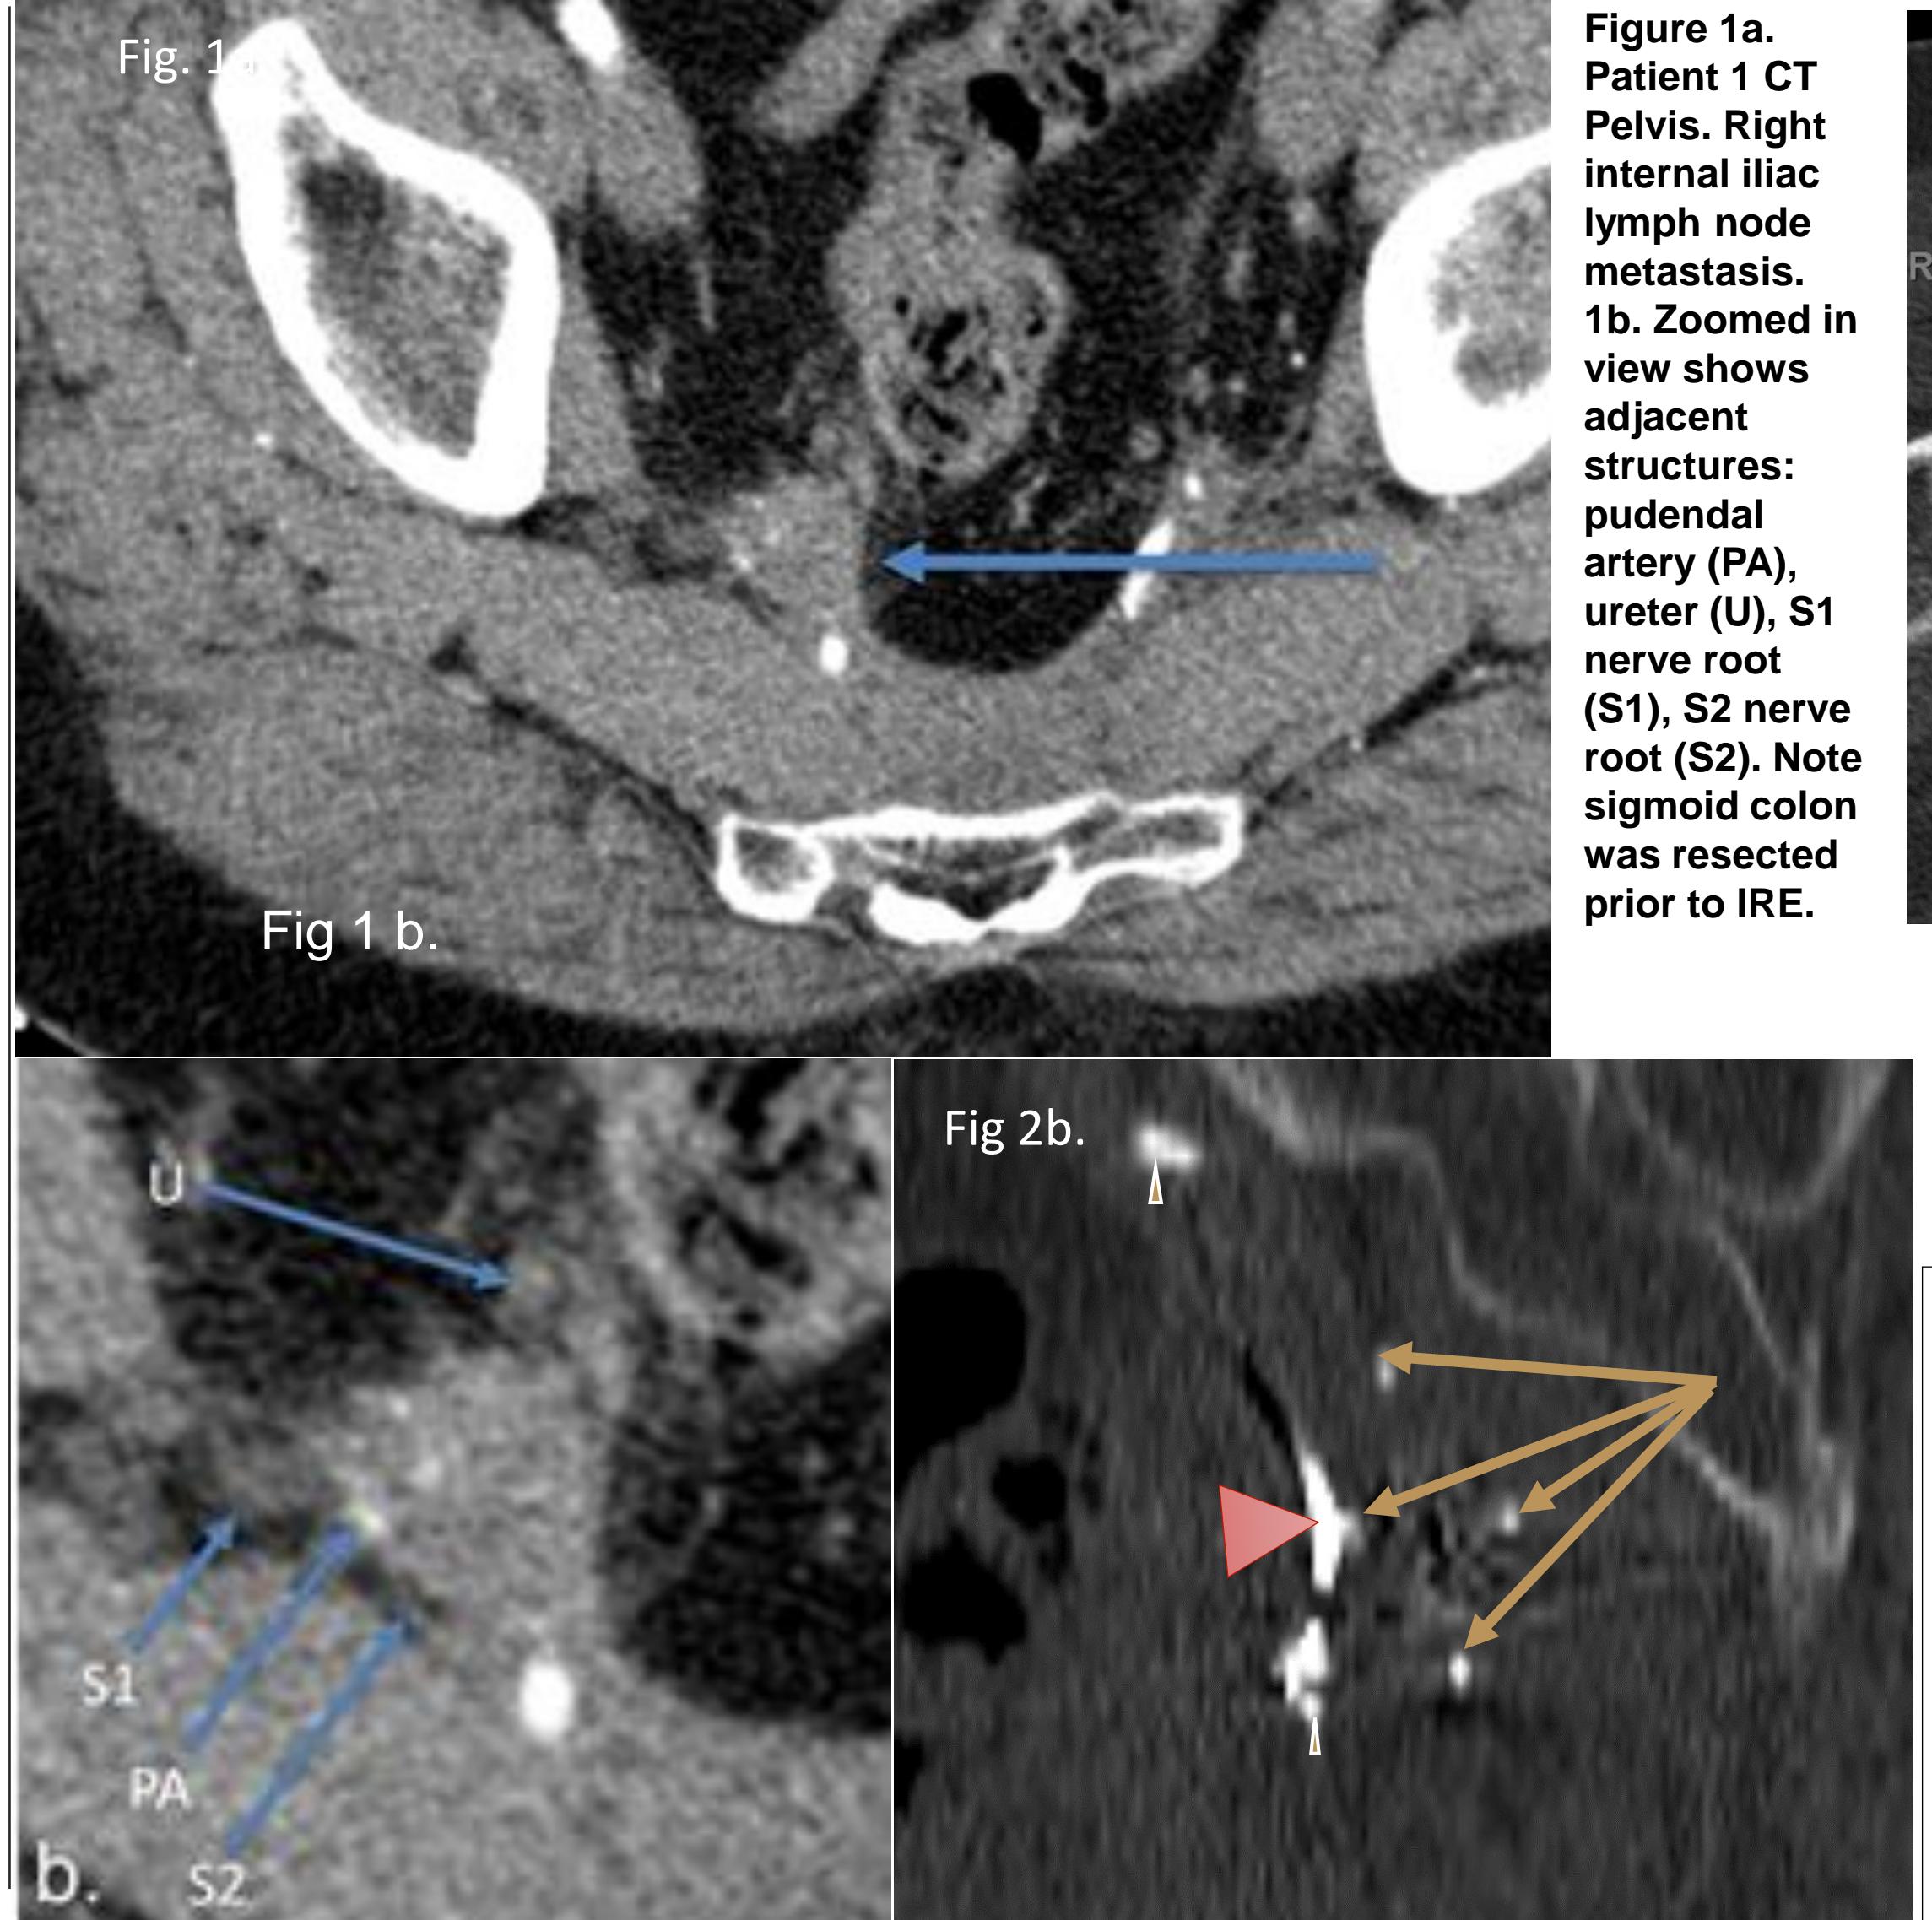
Patient 1 CT Pelvis. Right internal iliac lymph node metastasis.
